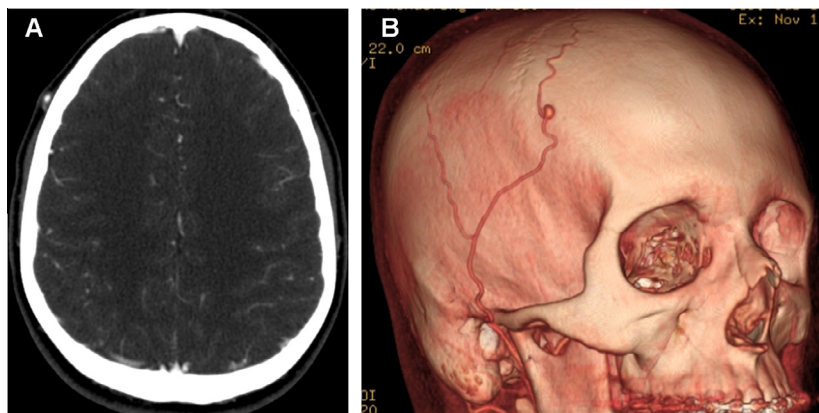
Patient 2. Axial CT angiogram (A) and three-dimensional CT angiogram (B) of the 7 mm pseudoaneurysm of the frontal branch of the right superficial temporal artery. (This figure is available in colour at www.sciencedirect.com)
